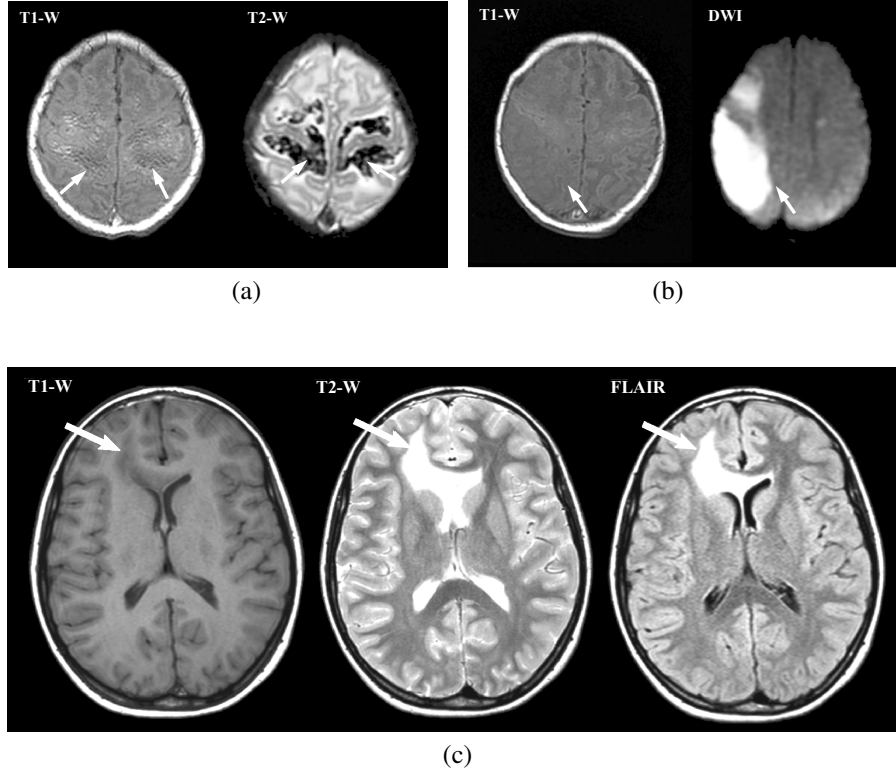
Examples of a brain lesion visibility using different MRI modalities. The lesions are indicated with arrows. (a) An example of a haemorrhage lesion hardly visible on the T_1 -W image (left), but clearly noticeable on the T_2 -W image (right). (b) An example of a big focal brain lesion only visible on the DWI image (right). (c) An example of a tumor lesion on T_1 -W, T_2 -W and FLAIR MR images. The tumor can be identified in all three cases, but the easiest on the FLAIR image. The first two examples (a) and (b) show a neonatal brain and the last example (c) shows an adult brain.
